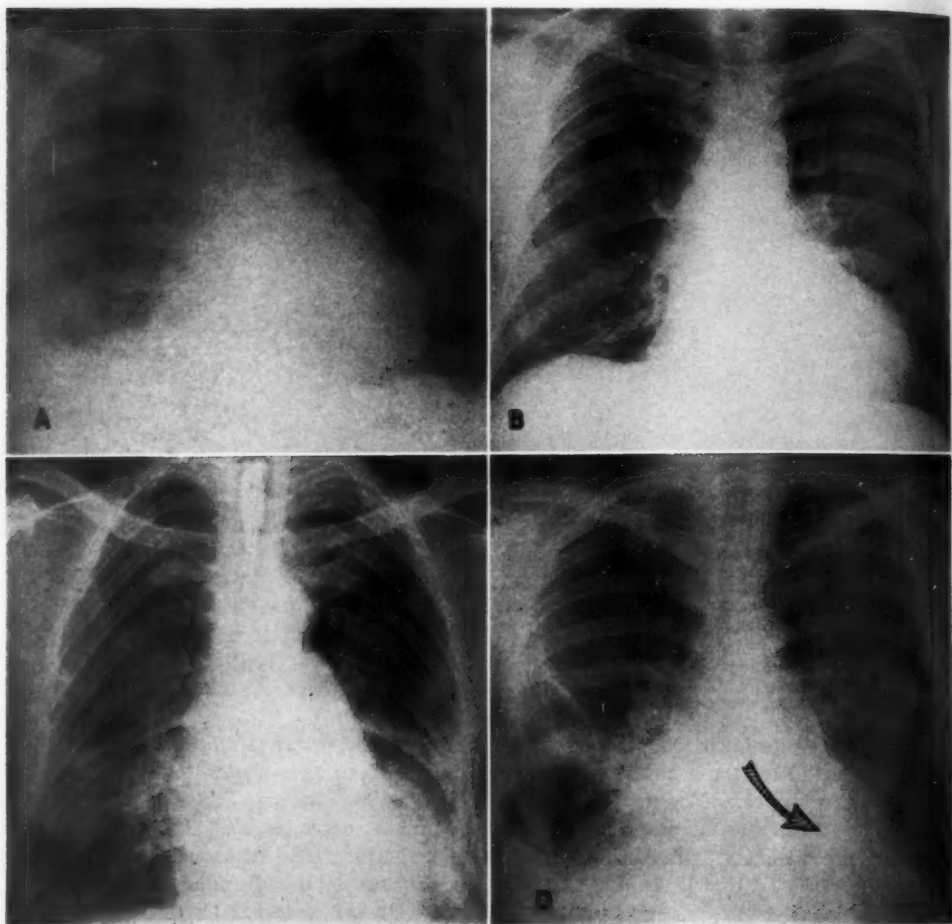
The variable roentgen silhouette of constrictive pericarditis.
